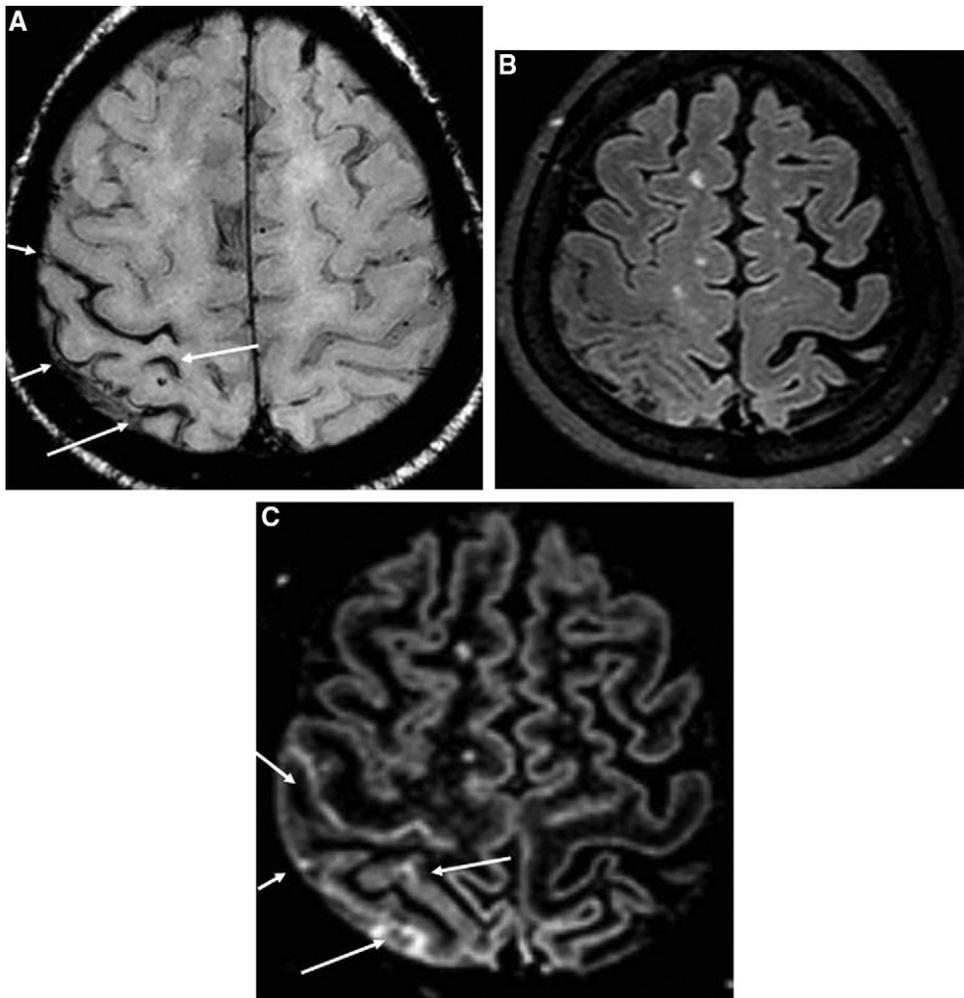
A 64-year-old woman with chronic SAH (2 months after onset). A. SWI images showing chronic SAH or superficial siderosis (arrows). B. Sulcal hyperintensity is not apparent on the 3D FLAIR image. C. 3D DIR showing sulcal hyperintensity (arrows).
